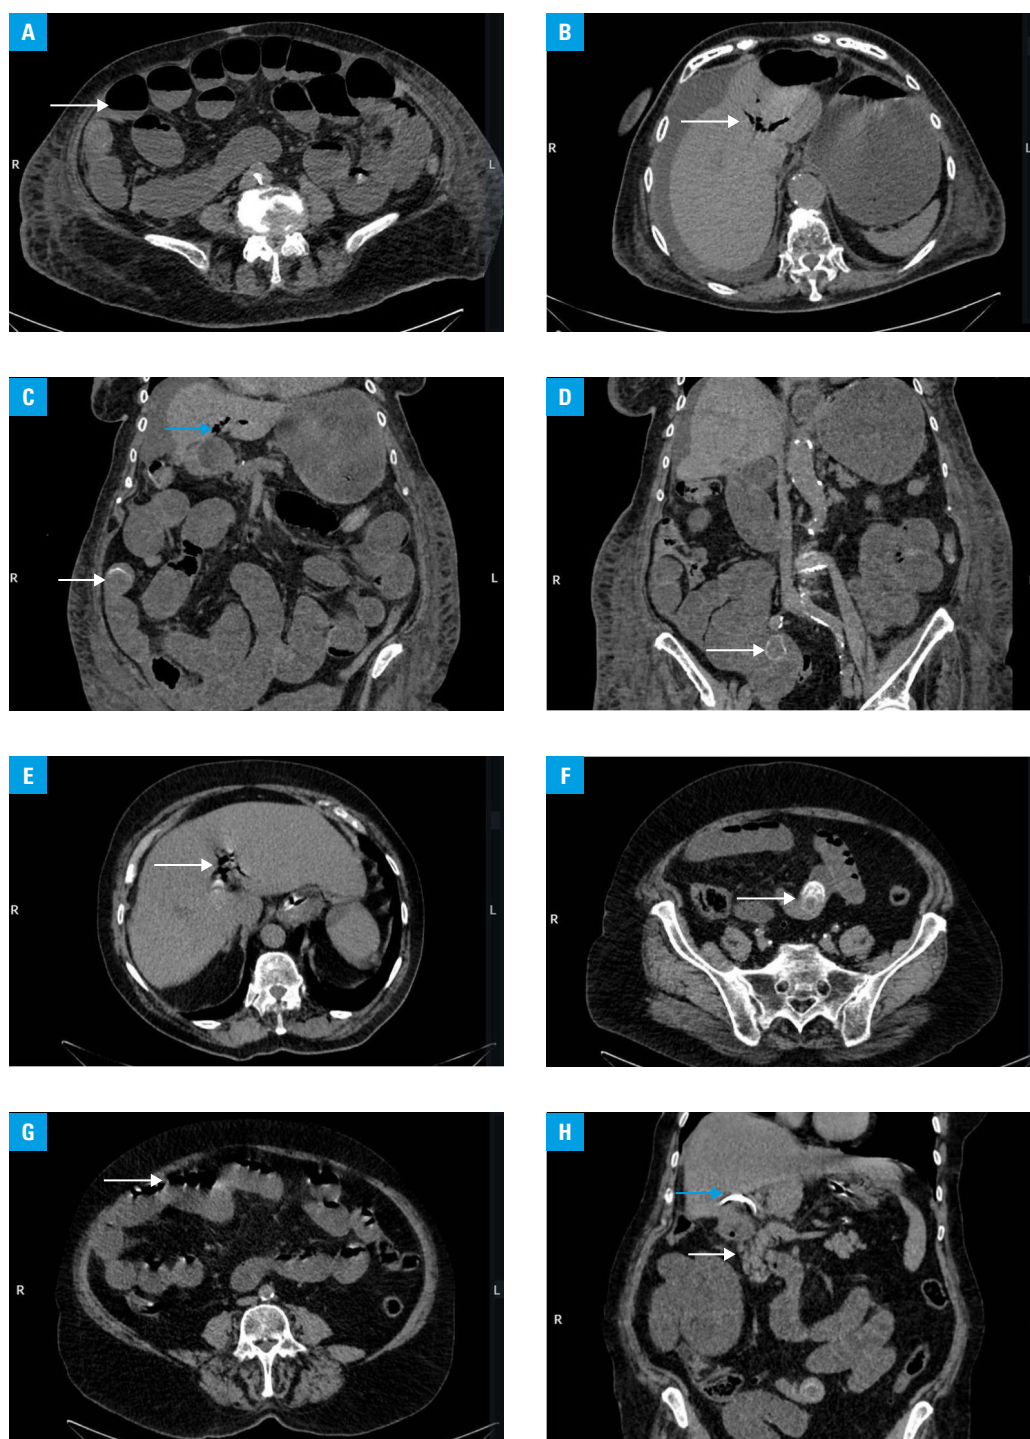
Computed tomography findings in 2 women operated due to gallstone ileus; A–D – patient 1, 90 years old; multiple gas-fluid levels within the small intestine (A, arrow), pneumobilia (B, arrow), pneumobilia (blue arrow) and an ectopic gallstone at the level of the umbilicus (white arrow) (C), and a second ectopic gallstone close to the right common iliac artery bifurcation (D, arrow); E–H – patient 2, 75 years old; pneumobilia (E, arrow), an ectopic gallstone in the distal ileum (F, arrow), gas-fluid levels within the small intestine (G, arrow), a cholecysto-duodenal fistula (white arrow), and a stent in the right hepatic duct (blue arrow) (H)
